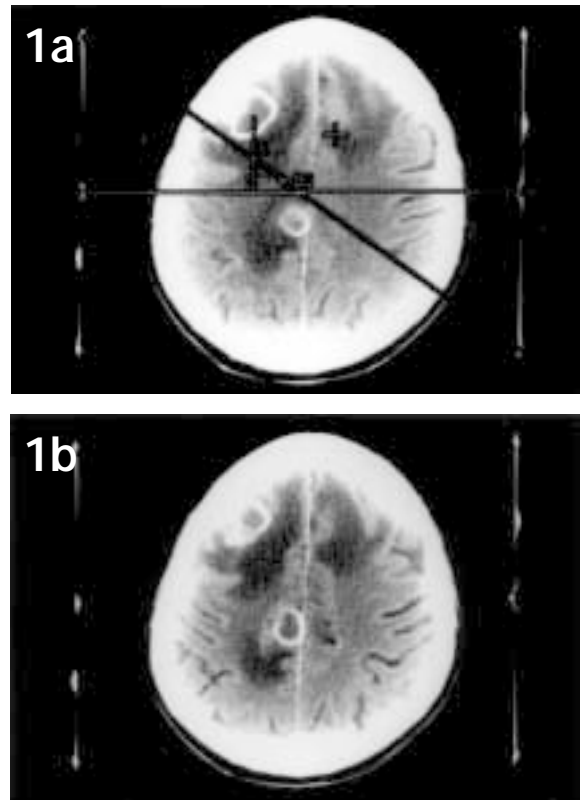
The CT appearance of the TB brain abscesses (ring enhancing lesions) before anti-TB treatment.
